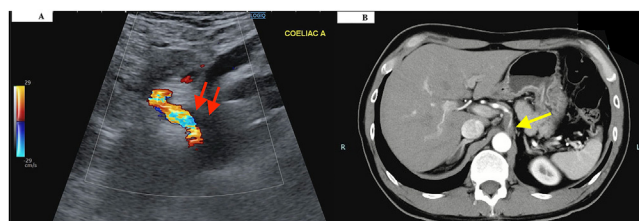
(A). Bedside abdominal ultrasonography demonstrated a dissection originating from the celiac artery root, consistent with an occlusive-type false lumen. The false lumen was completely thrombosed (red arrow), with a peak systolic velocity of 160 cm/s, and the true lumen showed approximately 60% stenosis. (B) Contrast-enhanced CT revealed a celiac artery dissection with mild dilatation of the vessel to 10 mm and marked luminal stenosis (yellow arrow). The false lumen was thrombosed, with slight extension into the common hepatic artery.
